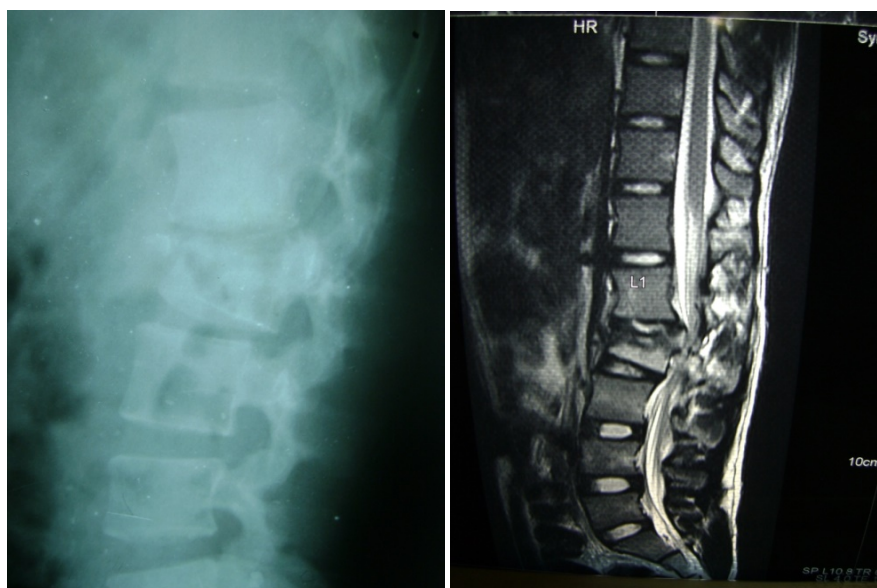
Preoperative Xray and MRI.
